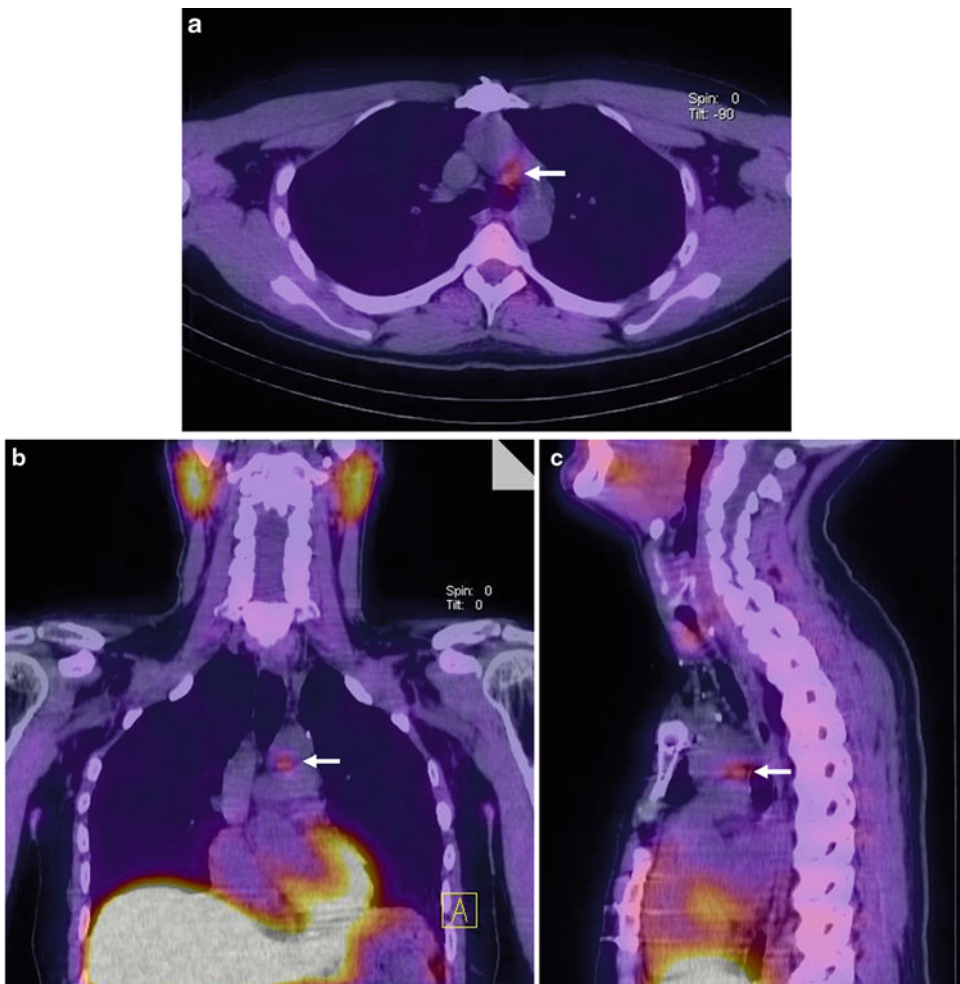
Ectopic parathyroid adenoma (*arrow*) in the aortopulmonary window. Coregistered sestamibi SPECT/CT tomograms in the transverse (a), coronal (b), and sagittal (c) planes
